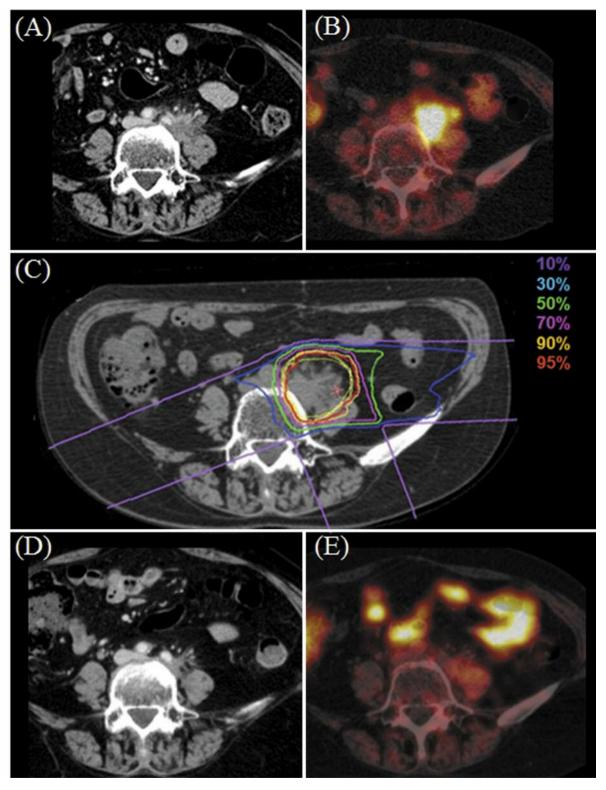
Common iliac lymph node recurrence with cervical cancer. (A) Enhanced axial CT image shows enlarged lymph node in left iliac area. (B) Axial FDG-PET image shows abnormal FDG uptake corresponding to enlarged common iliac lymph node. (C) Dose distribution of C-ion RT for common iliac lymph node recurrence. Isodose curves of C-ion RT are superimposed on an axial CT image for the total irradiation plan. Highlighted are 95% (red), 90% (orange), 70% (pink), 50% (green), 30% (blue), 10% (purple) isodose curves (100% was 52.8 Gy (RBE)). (D) Enhanced axial CT image 18 months after C-ion RT. (E) Axial FDG-PET image 12 months after C-ion RT shows no abnormal FDG uptake.
